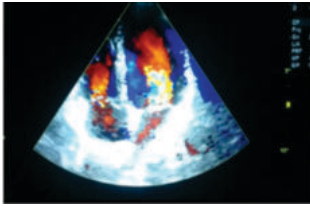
apical four chamber with colour flow study
